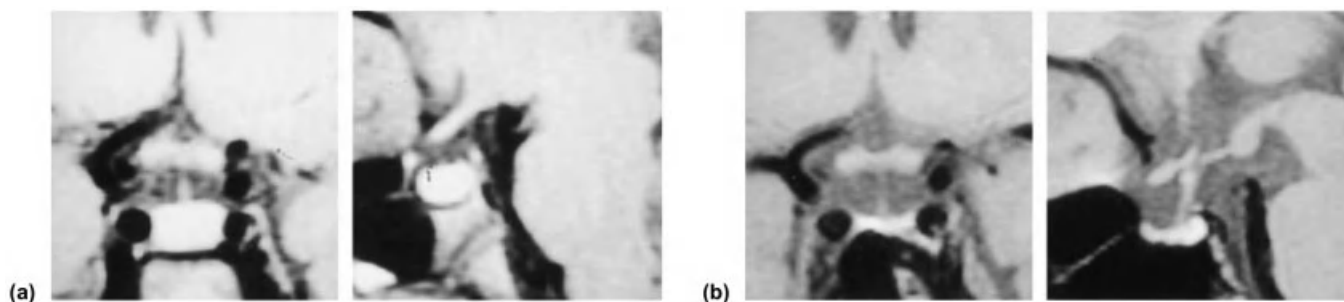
MRI of a patient with A301, G302 deletion in *PROP1*. (a) At 8.8 years, neuroimaging revealed an enlarged anterior pituitary. (b) Repeat scan at 15 years demonstrated spontaneous involution with a pituitary gland of reduced size. Taken from Mendonca BB *et al.* *J Clin Endocrinol Metab* 1999; 84: 942–5.
